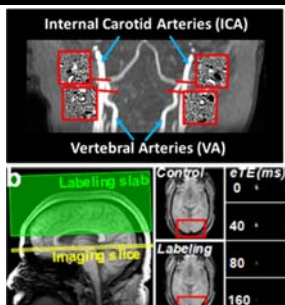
CMRO2 technique; a) Phase contrast technique applied at arteries feeding into brain, b) TRUST MRI applied at the sagittal sinus
